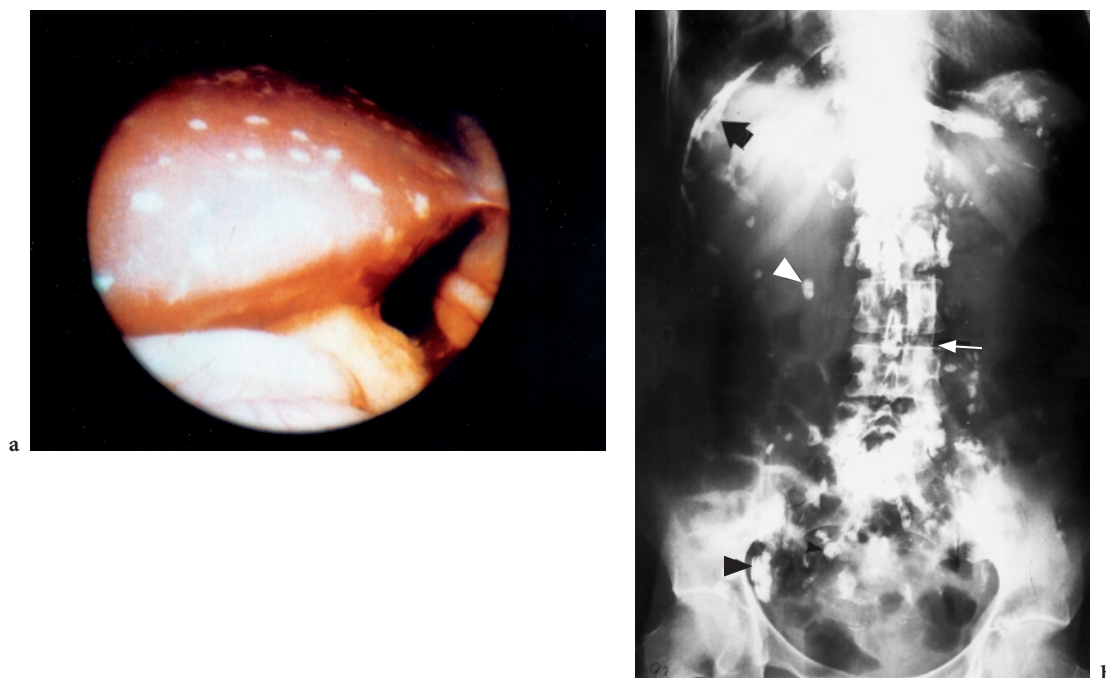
Tuberculous peritonitis. A 50-year-old woman presenting with low-grade fever, weight loss, diffuse abdominal pain, and abdominal distension of 6 months duration. Clinical examination revealed abdominal tenderness and free fluid in the peritoneum. ESR was 60 mm and PPD skin test was 25 mm. X-ray chest revealed right apical infiltration and scarring. Ascitic fluid analysis revealed low-gradient lymphocytic exudate. a Laparoscopic examination revealed adhesions, peritoneal exudates, and multiple small (3 to 5 mm), whitish, elevated lesions on the visceral and parietal peritoneal surface. In this photograph multiple such lesions are shown on the liver surface. The results of a peritoneal biopsy from this patient are shown in Fig 37.10 b Plain X-ray of abdomen showing plaque-like calcification in the right and left upper quadrant (peritoneum - *thick arrow*), nodular calcification in the abdomen (lymph nodes - *arrowheads*), and incidental atherosclerotic linear calcification along the aortic wall (*arrow*).
